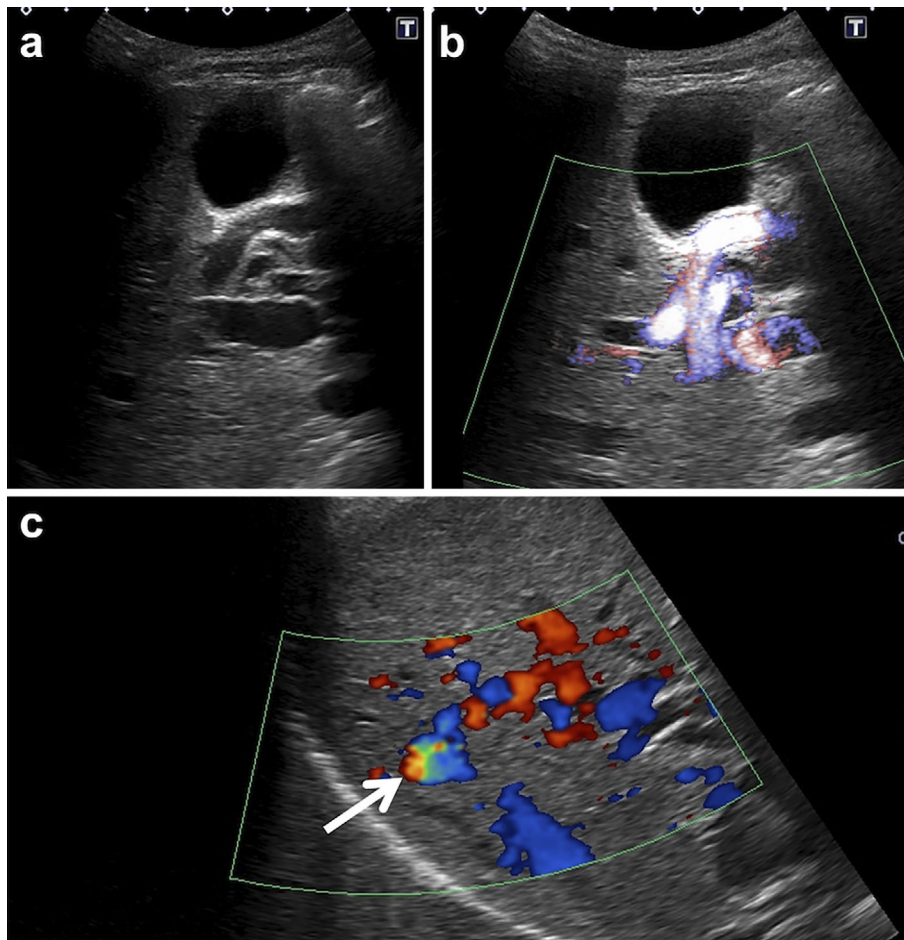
Abdominal ultrasonography showed multiple anechoic structures in the liver (a). Flow was confirmed on color Doppler imaging, and the anechoic structures were considered to be dilated and tortuous vessels (b). Color Doppler imaging showed hepatic arteriovenous shunts with a turbulent flow (c, arrow).
